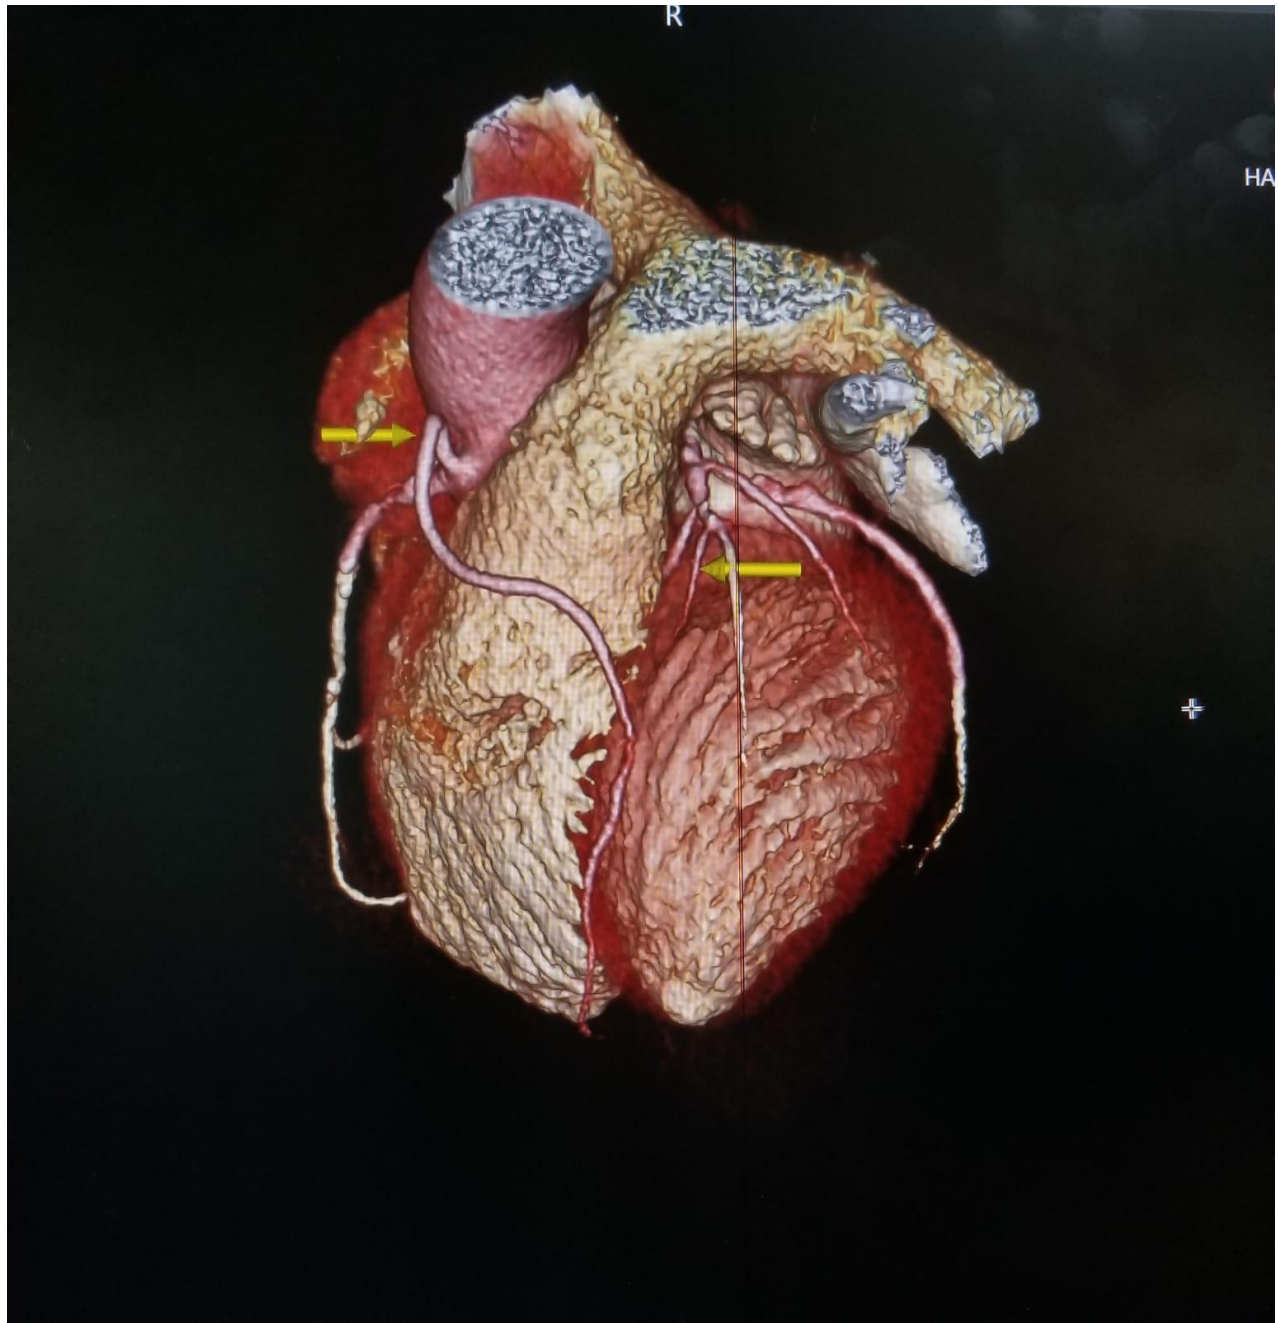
3D volume-rendered CT coronary angiography (CTCA) image showing dual LAD
